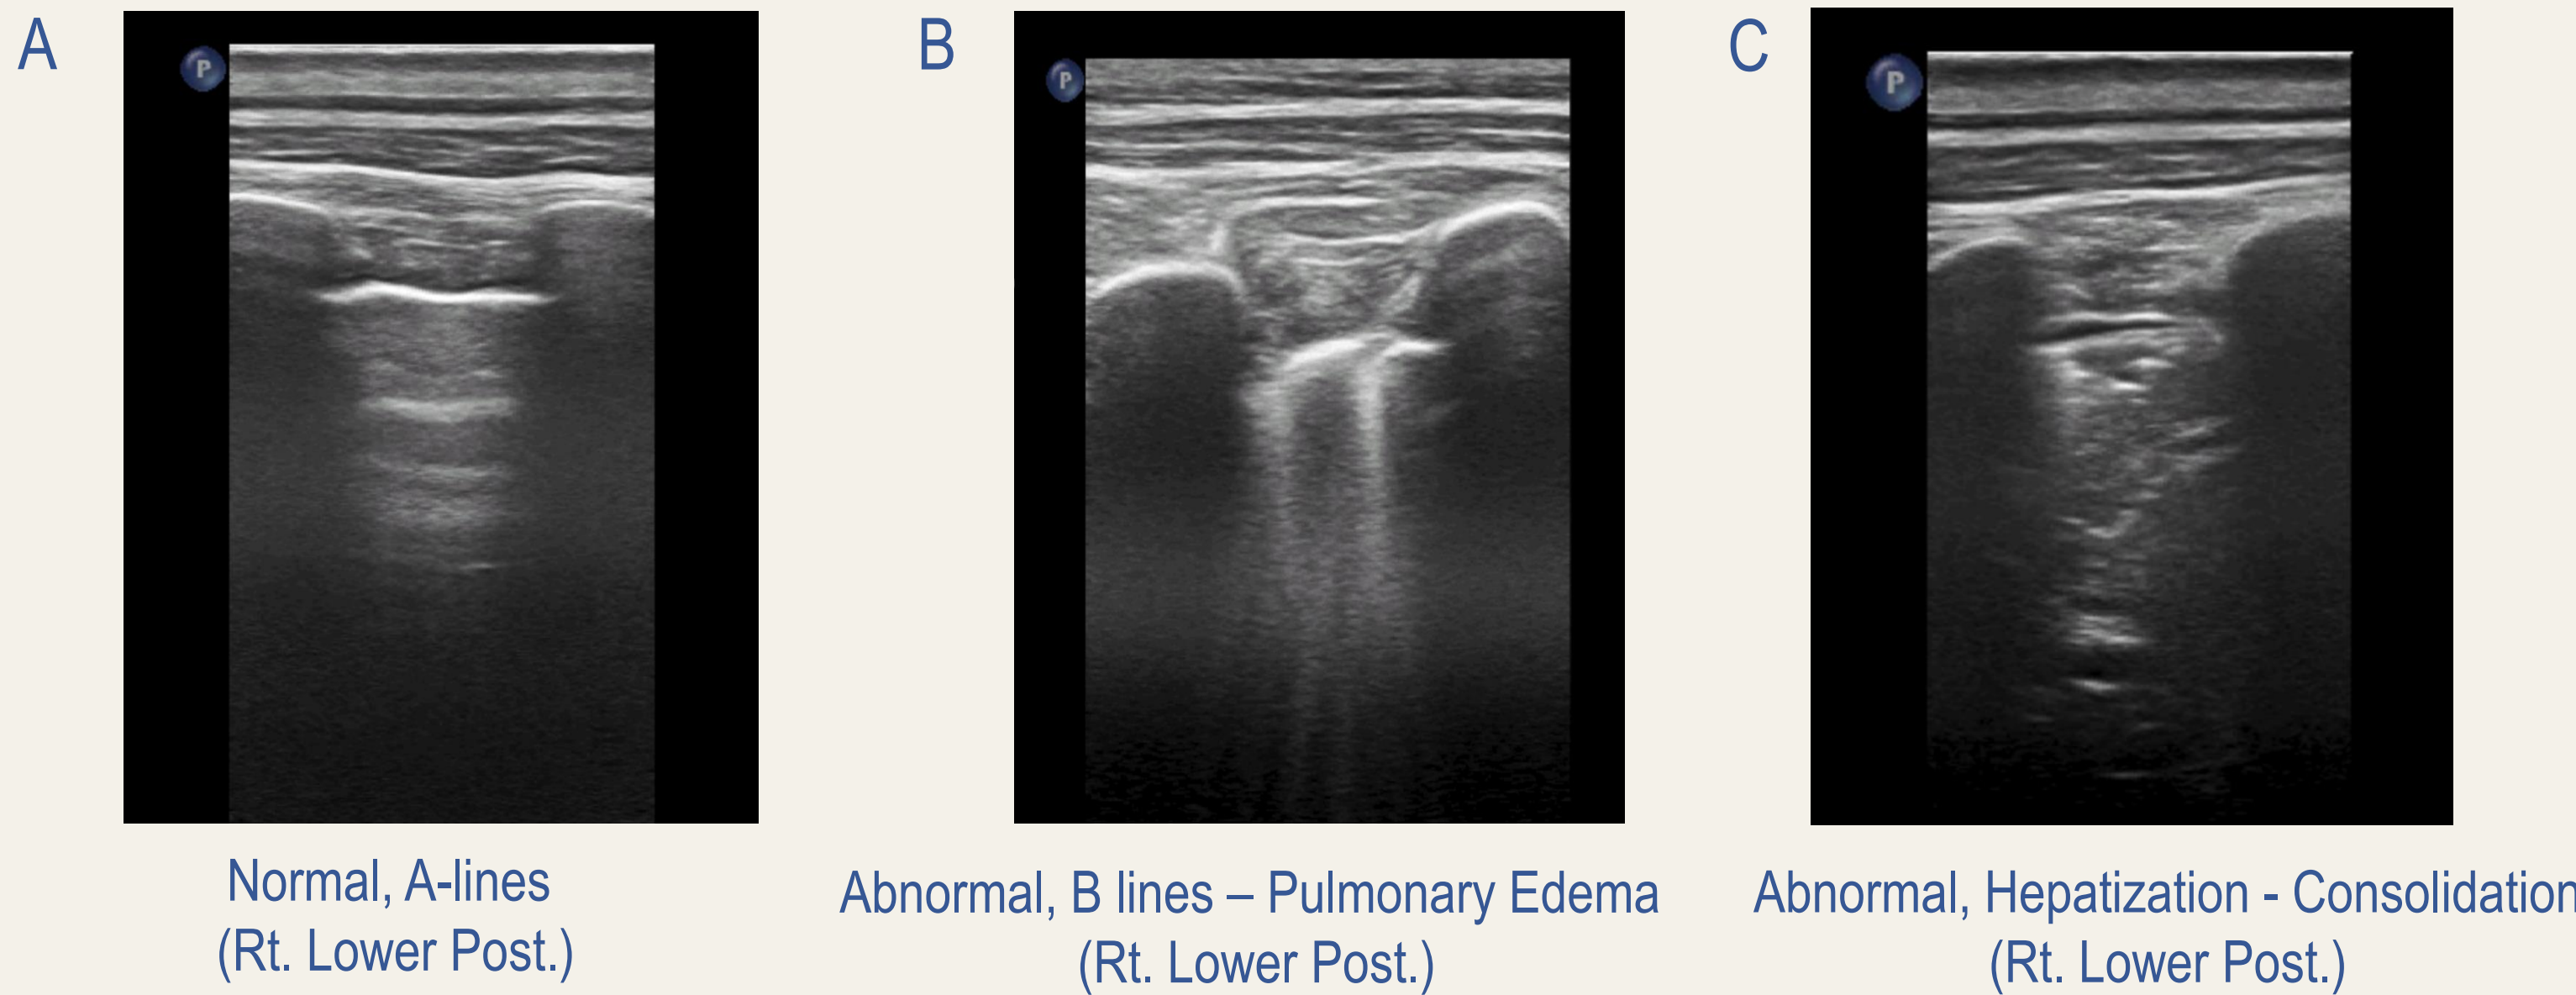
Lung Ultrasound pictures of Normal A=lines (A), and Abnormal numerous B lines (B) and lung hepatization (C).
